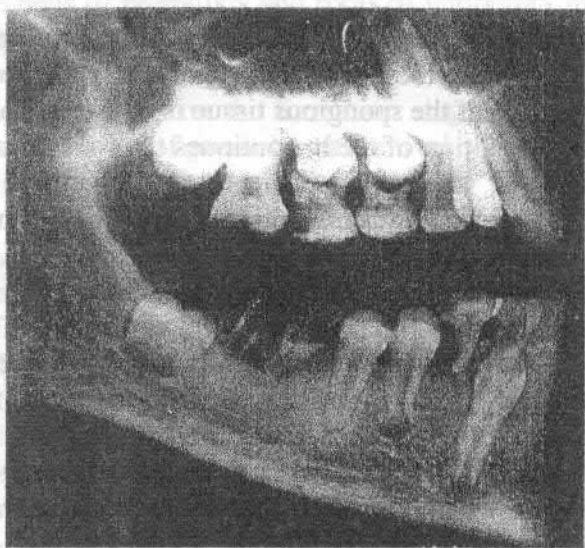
Radiography of maxillaries at the age of 5 years*
